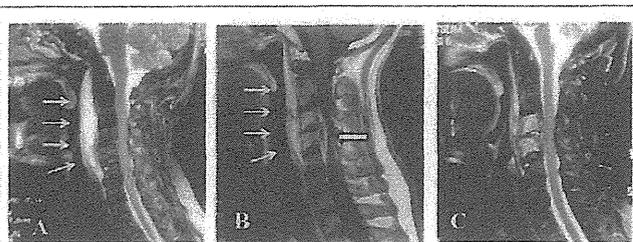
Sagittal cervical MRI of case 1. (A) T2-weighted image on admission. Small arrows indicate the abscess in retropharyngeal space extended from C1 to C5 level. (B) Gadolinium-enhanced T1-weighted image 7 days after admission. Epidural abscess was observed in C3 to C5 level (large arrow). (C) T2-weighted image 15 days after admission. Epidural abscess was disappeared and retropharyngeal space was decreased.
